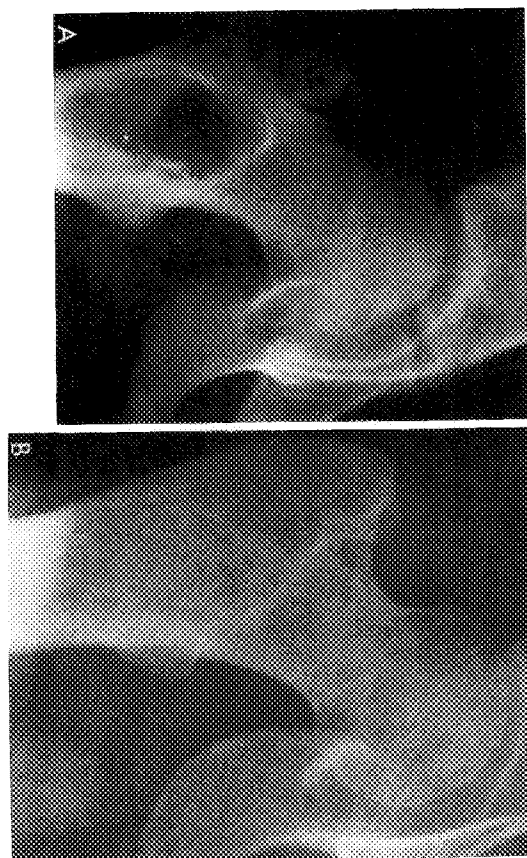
A*, A large radiolucent lesion in the proximal femur of a young girl, age 12. Biopsy confirmed the lesion as showing fibrous dysplasia. Curettage and grafting were not performed. *B*, Radiograph ten years subsequently with marked healing of the lesion.
